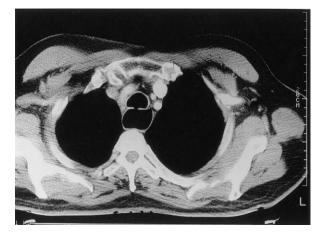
Computed tomogram of a congenital TEF.
